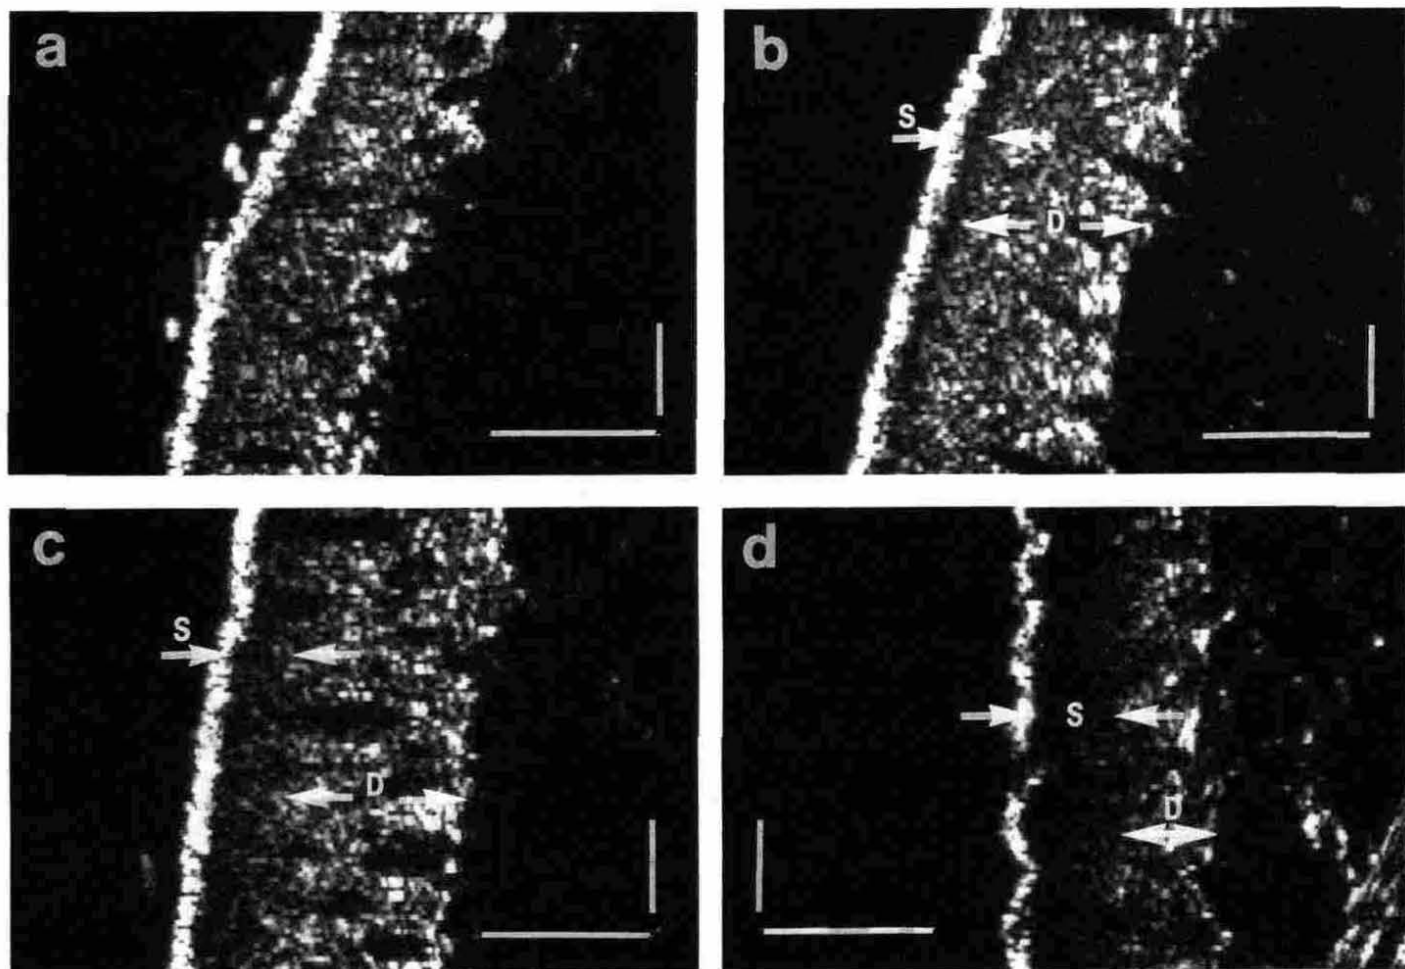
High resolution ultrasonic images of the human skin from (a) a child (6 years), (b) a young adult (31 years), (c) an older adult (49 years), and (d) an aged woman (78 years). Vertical bar: 5 mm; Horizontal bar: 1 mm; S: SENE; D: DEB.
